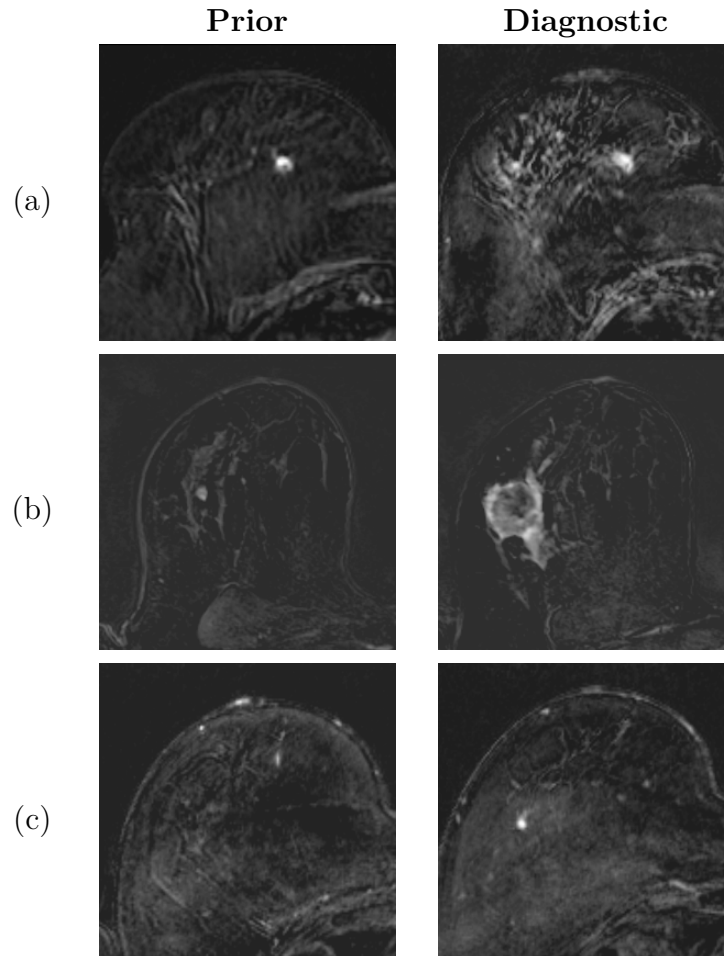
Subtracted images with breast cancer lesions which are (a) visible, (b) minimally visible and (c) not visible on the prior DCE-MRI study. BI-RADS scores were 1 and 4, 2 and 5, and 1 and 3 for prior and diagnostic of (a), (b) and (c), respectively
